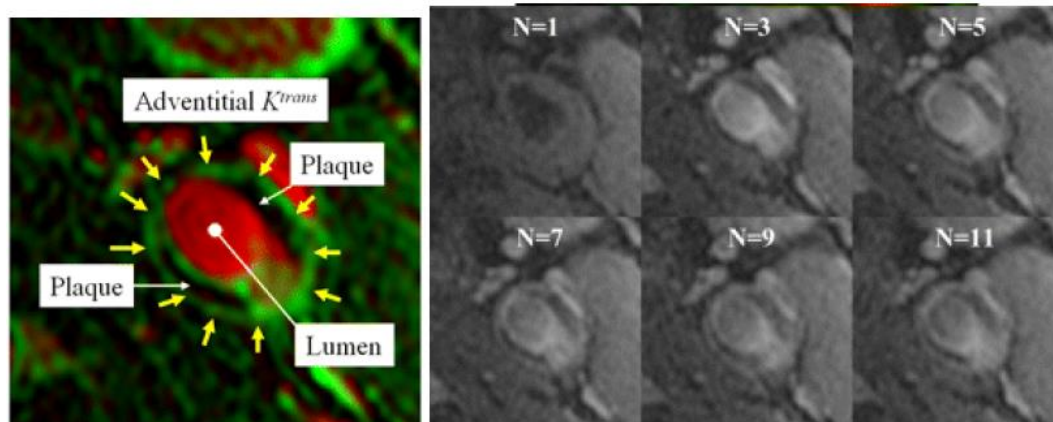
Left:* Kinetic analysis of dynamic contrast enhanced MRI of carotid atherosclerosis yields a parametric image “vasa vasorum” displaying the value of fractional blood volume (v_p) in red and transfer constant (K^{trans}) in green. The rapid transfer in the vessel adventitia is indicated using yellow arrows. *Right:* Image is derived from kinetic modeling of changing intensity in serial images coinciding with contrast agent.
